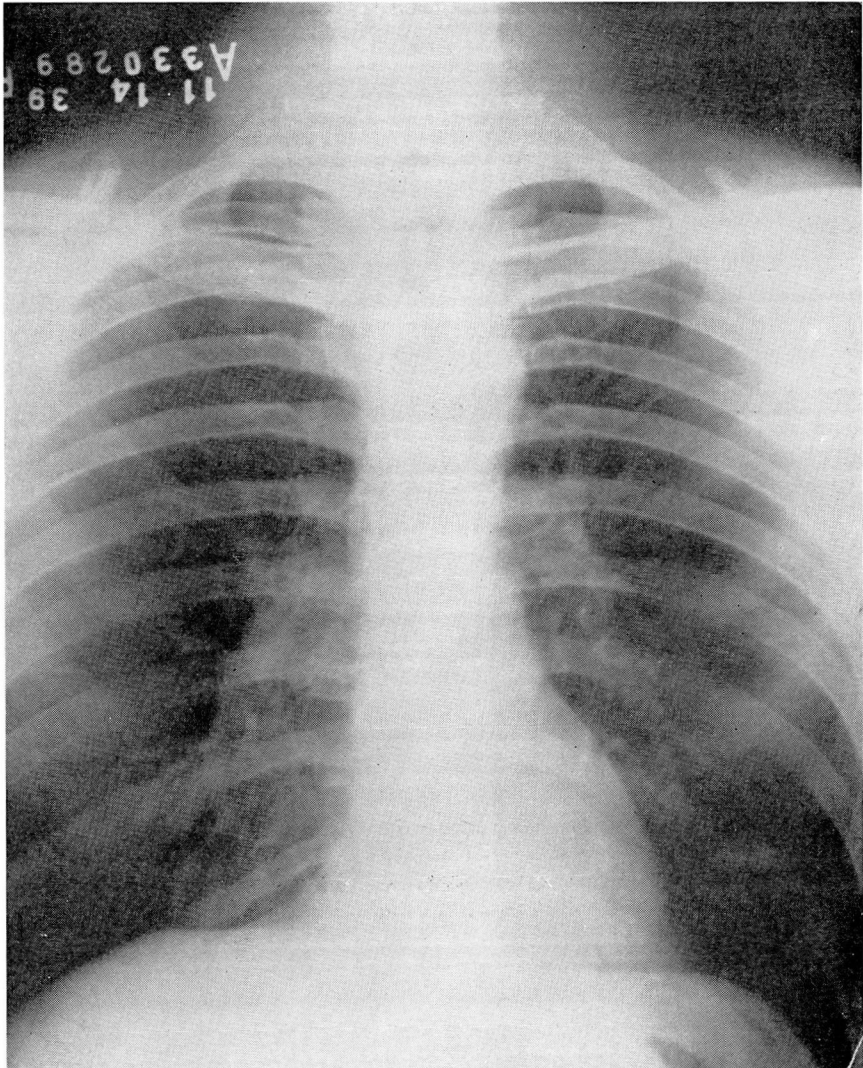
Roentgenogram taken twenty days after institution of treatment, showing a considerable clearing of the infiltration.
